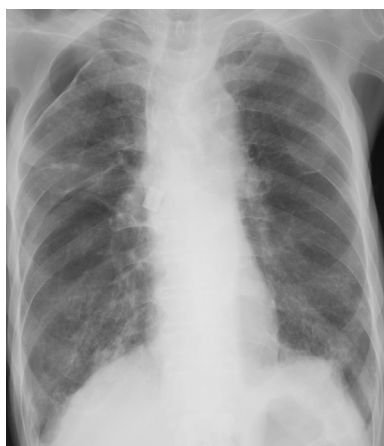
Chest radiography showing that the capsule is located within the bronchus intermedius and right pneumothorax.
